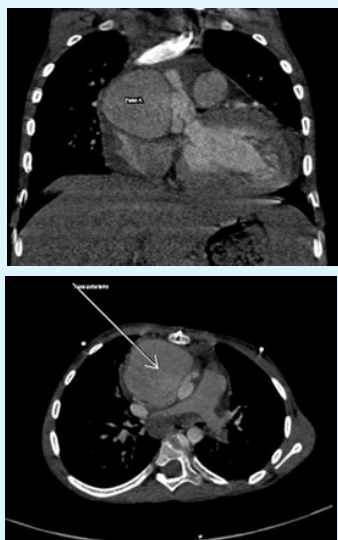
Contrast-enhanced cardiac CT -coronal and axial reconstructions.
